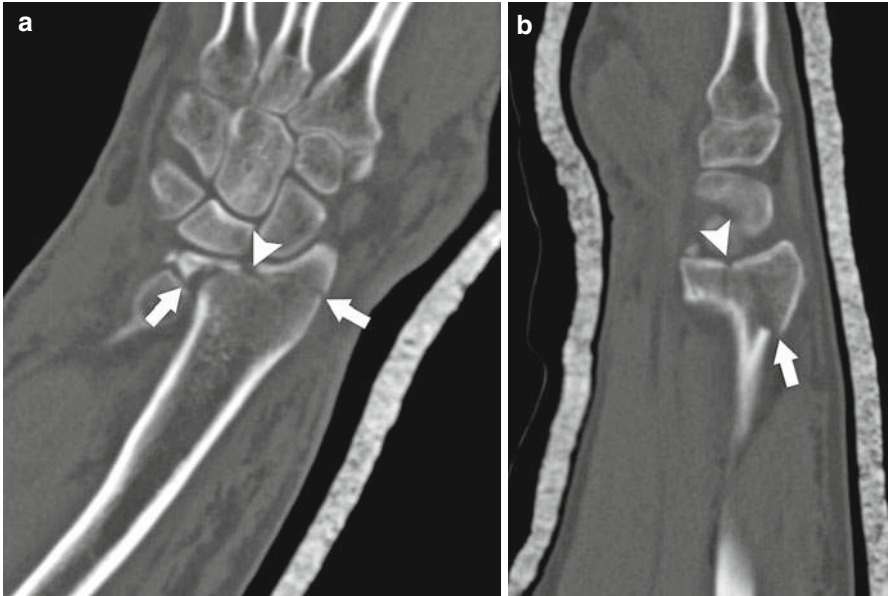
Intra-articular distal radius fracture. Wrist CT with anteroposterior (a) and lateral (b) reconstructions reveals a comminuted fracture of the distal radius (arrows) extending into the radiocarpal joint (arrowhead)
